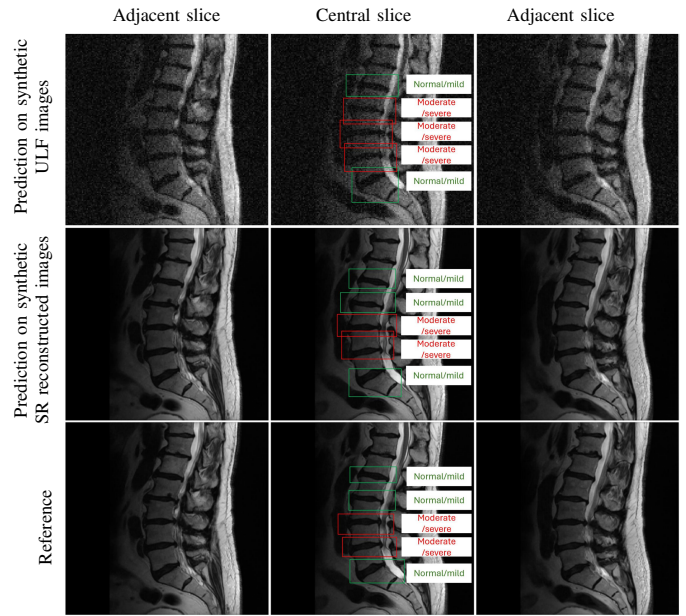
IVDD detection results of synthetic ULF MRI data and the corresponding synthetic SR reconstructed data from one subject with disc degeneration in the per-lesion level. The model could perform better on synthetic SR reconstructed data. This indicates that the detection model performance could be improved after introducing SR reconstruction.
